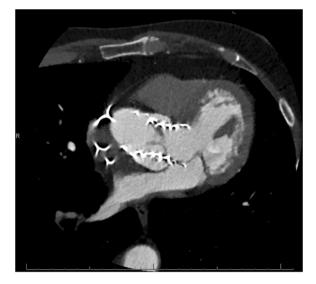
Computed tomography image demonstrating hypoattenuation of the right cusp of TAVI prosthesis consistent with a focal area of thrombus
